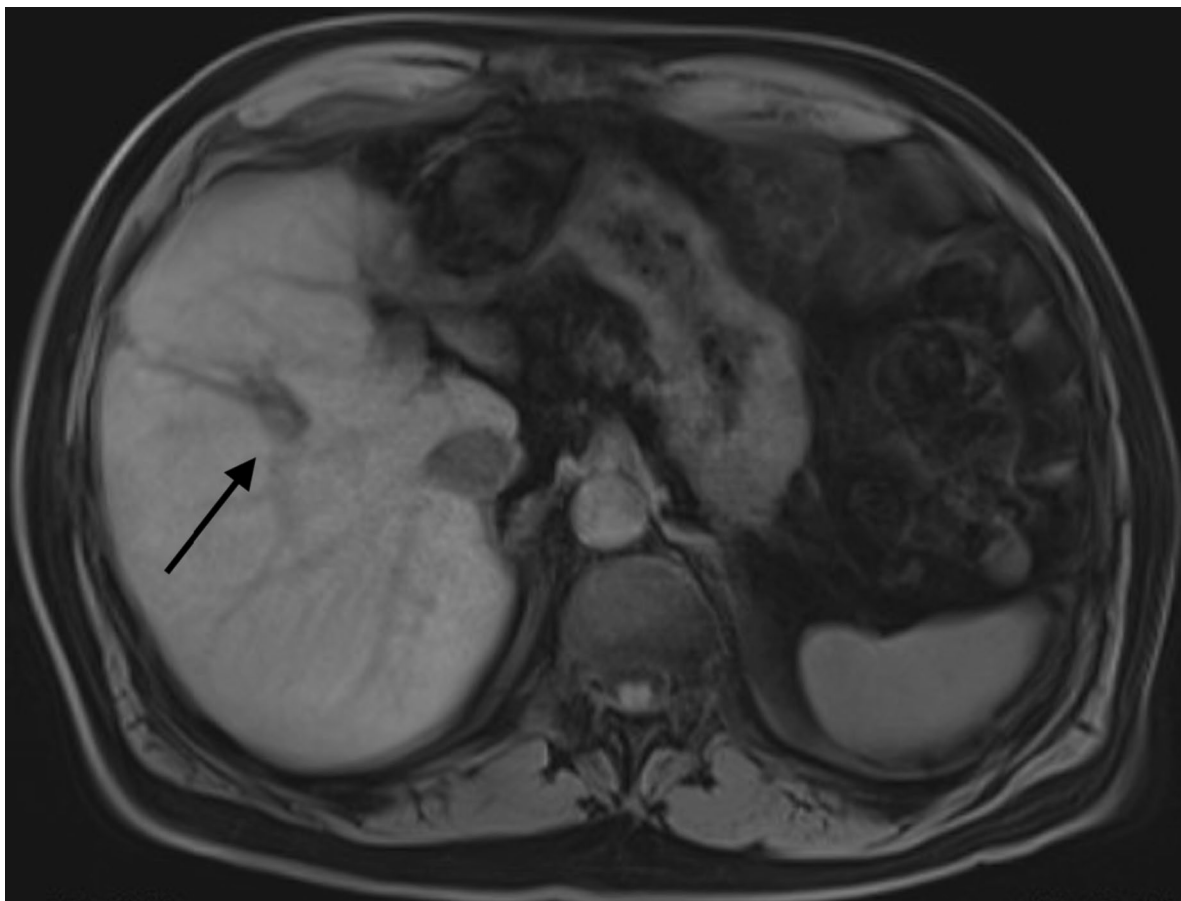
CT axial image demonstrating infiltrating cholangiocarcinoma causing biliary obstruction and resultant atrophy in the left lobe of the liver
